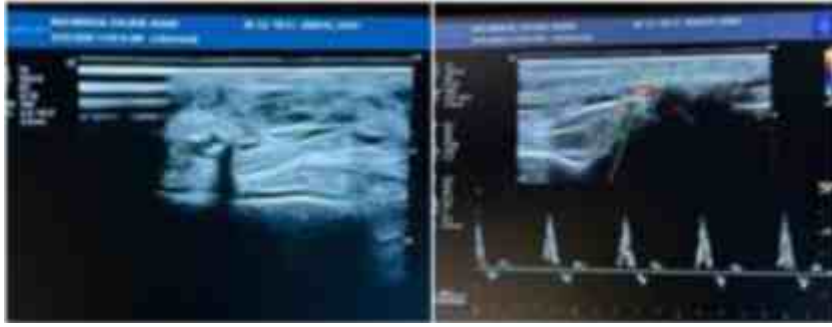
A 38-year-old male patient with uncontrolled diabetes, HbA1c of 8, (A) Wall thickening along anterior tibial artery (ATA) on gray scale, (B) Color Doppler showing aliasing but normal triphasic waveform on spectral Doppler.
